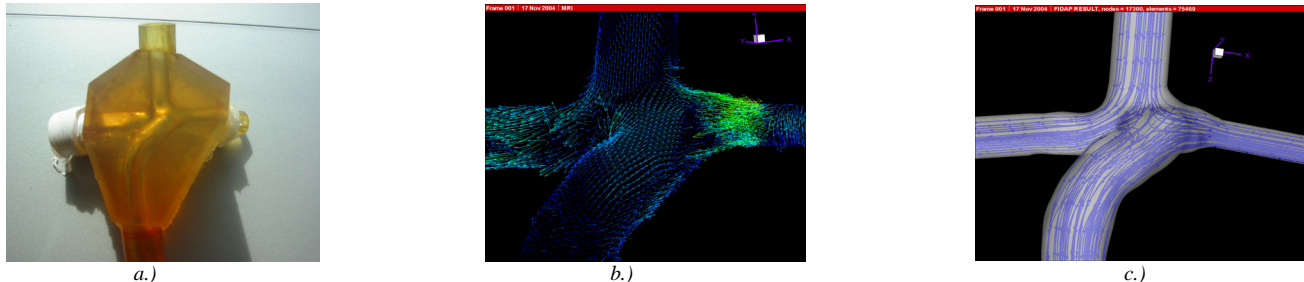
a) A physical anatomical model used for running the experiment, b.) MRI flow field reconstruction, c.) CFD results
